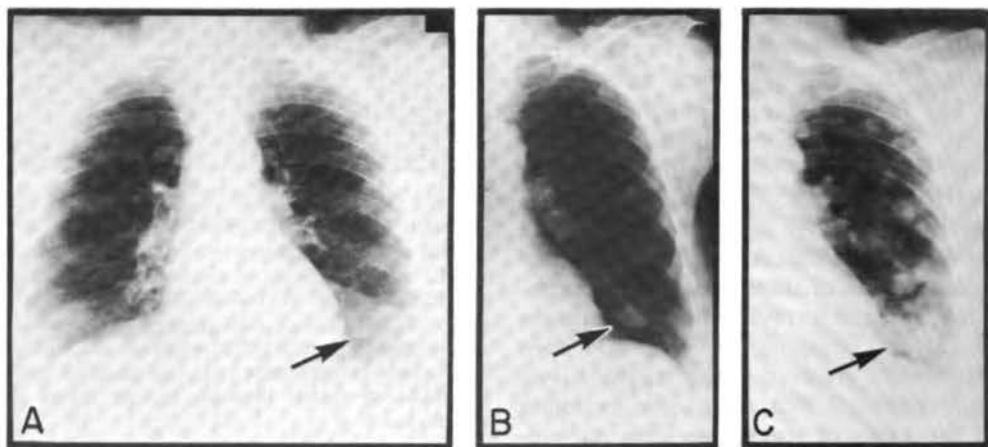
Progression of pulmonary metastasis in a patient with stage III disease, between commencement of ^{60}Co irradiation with OHP (A), termination of the 6-week course of radiation therapy (B), and 6 weeks after completion of therapy (C). The time required for the tumor to double in volume was approximately 21 days, both during and after irradiation in OHP. Unfortunately we cannot assume this doubling time to be constant from initial seeding to commencement of OHP therapy. It is possible, of course, that the pulmonary metastases were well enough oxygenated between seeding and the time when tumor was first detected on x-ray film (just before treatment) that no change in doubling time occurred.
